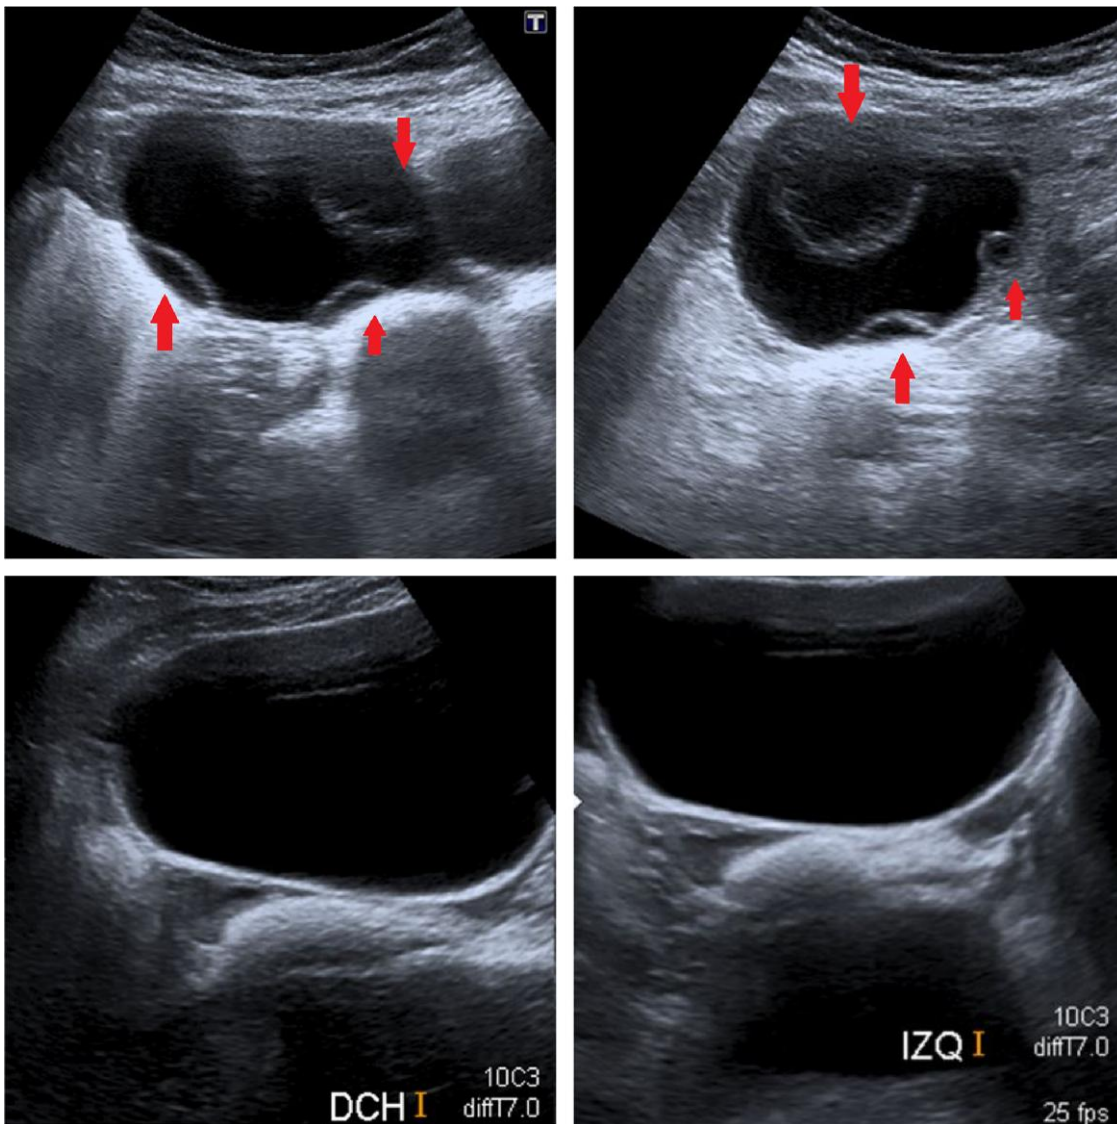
Pelvic ultrasound before (above) and after (below) starting treatment. Arrows point to ovarian cysts.
